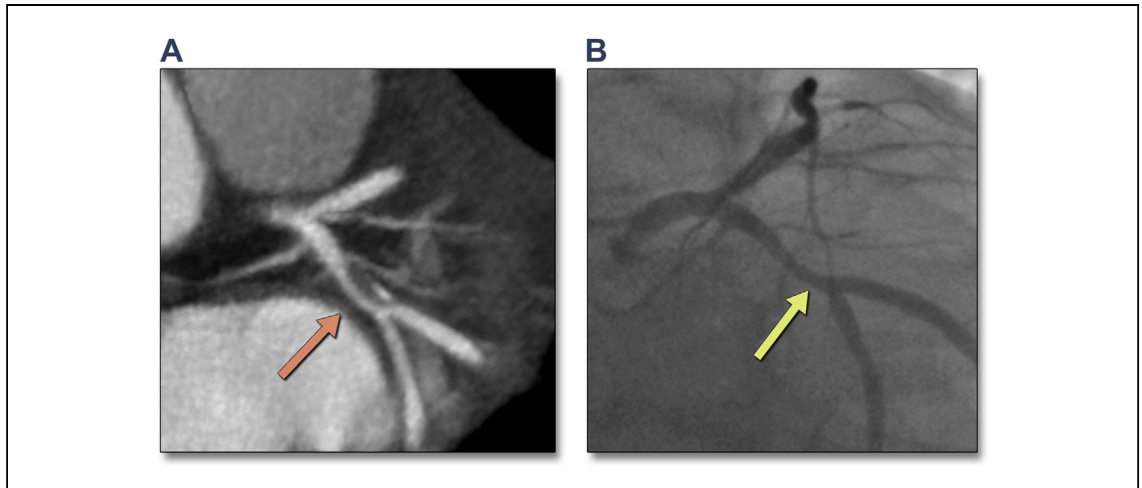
Minor Cardiac Motion Affecting the Quantification of Coronary Artery Stenosis by CTA
